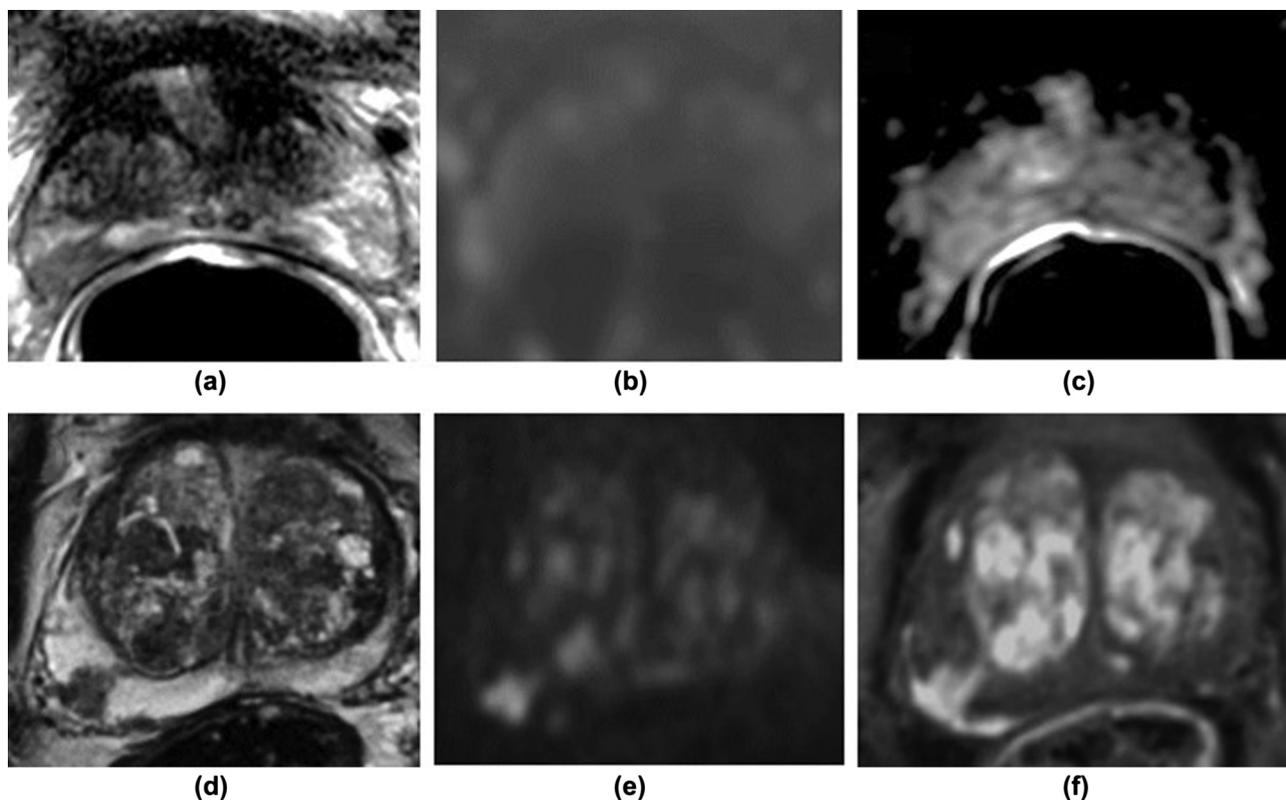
ERC distortion effect. Top Row: 1.5 T ERC imaging. (a) T2WI shows a focal area of low T2 signal in the right mid PZ. (b,c) No restricted diffusion on b-value imaging (b) or ADC maps (c), the dominant PZ sequences. Bottom row: same patient with repeat imaging at 3 T with a pelvic phased-array coil. Right mid-gland PZ lesion is well demonstrated on T2WI (d) and with marked restricted diffusion on b-value DWI (e) and additional early enhancement at DCE (f). Lesion confirmed as Gleason grade 4+3 on targeted biopsy. Image courtesy of Dr Clare Allen, UCL, London.
